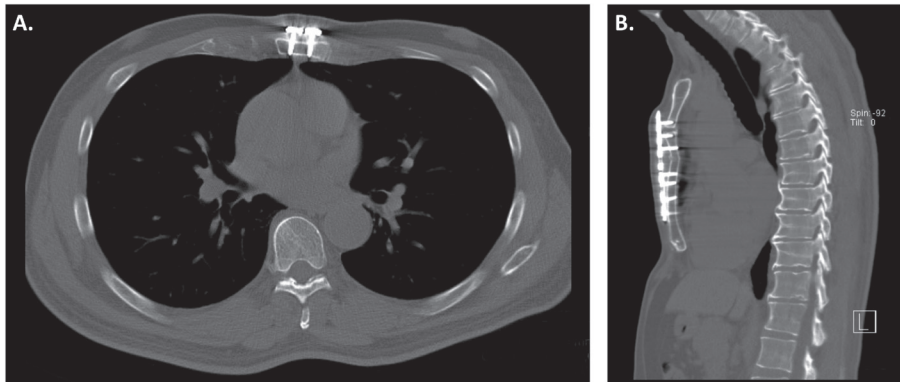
Postoperative CT-scan after locking compression plate osteosynthesis.
